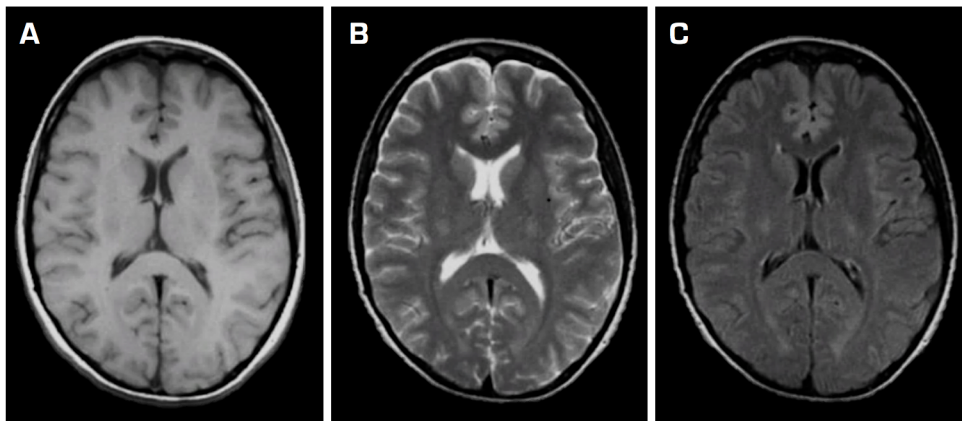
(a)  $T_1$ -weighted; (b)  $T_2$ -weighted; and (c) fluid-attenuated inversion recovery (FLAIR) images have different contrasts that reveal specific information about various structures in the brain.
